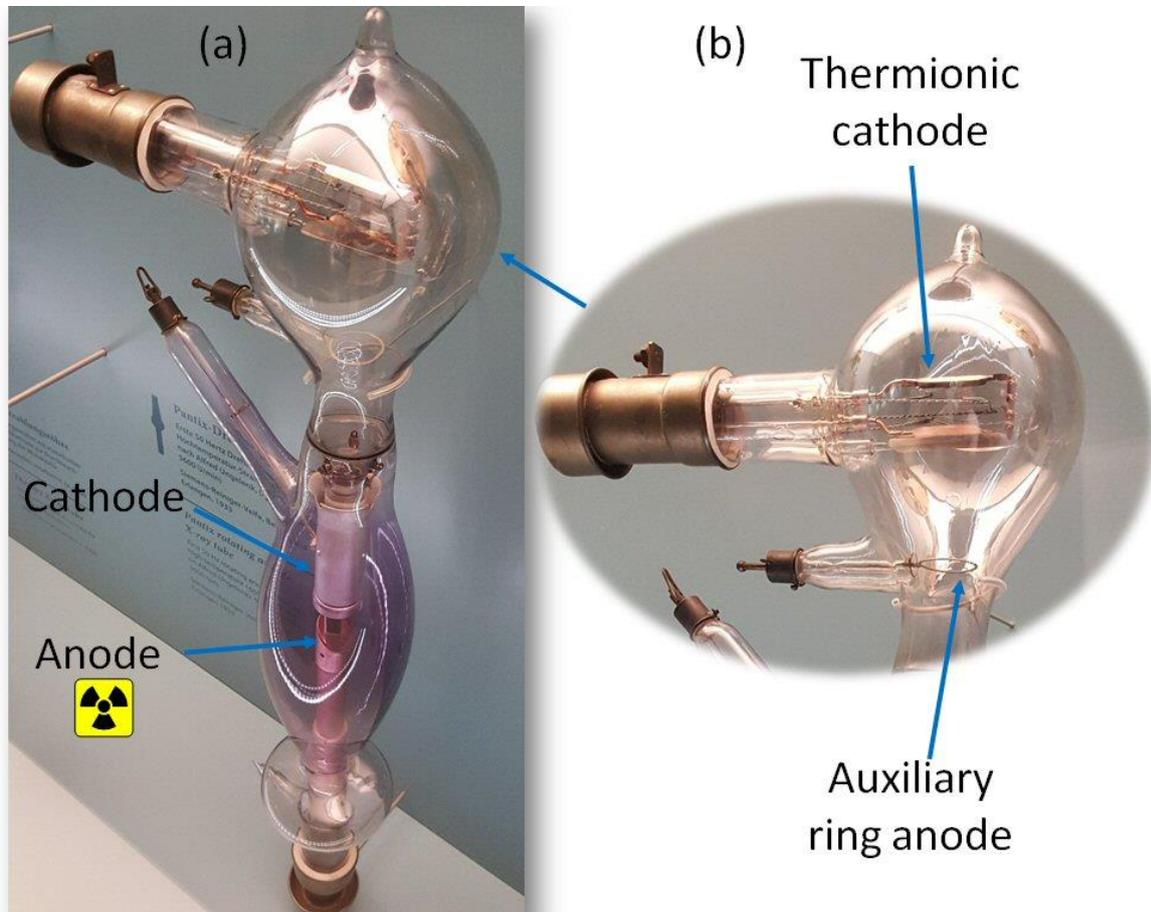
(a) Lilienfeld ion X-ray tube with thermionic electron production to pre-ionize residual gas. (b) Thermionic electron X-ray “softener”, an electron source with auxiliary anode to pre-ionize the residual gas. This model marks the transition between ion tubes and high vacuum tubes. (Photo taken at the German Röntgen Museum, Remscheid-Lennep, Germany.)
